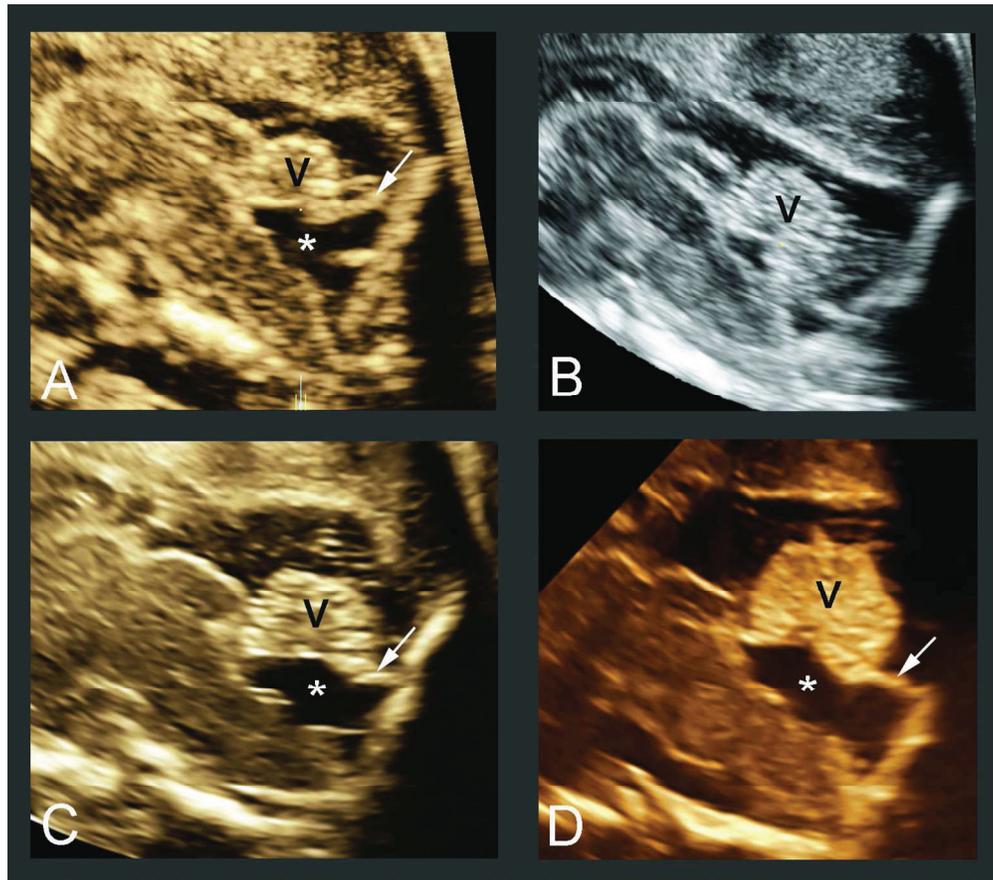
BPC can undergo delayed fenestration (A-B) or persist until birth (C-D). Midsagittal view. A) BPC at 20 weeks of gestation: the classic aspect of BPC is seen, with an anatomically normal vermis (V) showing anticlockwise rotation. The BPC (asterisk) and its roof (arrow) are visible; B) the same case at 28 weeks of gestation: the vermis (V) is no longer rotated anticlockwise, and has returned to its normal position close to the pons. A normal IV ventricle is visible (it was not before), and there is not any sign anymore of the former BPC. C) another case of BPC detected at 22 weeks of gestation. For description and captions see A; D) at 33 weeks of gestation, the situation is the same, with an anticlockwise rotated vermis (V), the BPC (asterisk), with its roof (arrow). The same image was present also on postnatal MRI performed at 1 month of age.
